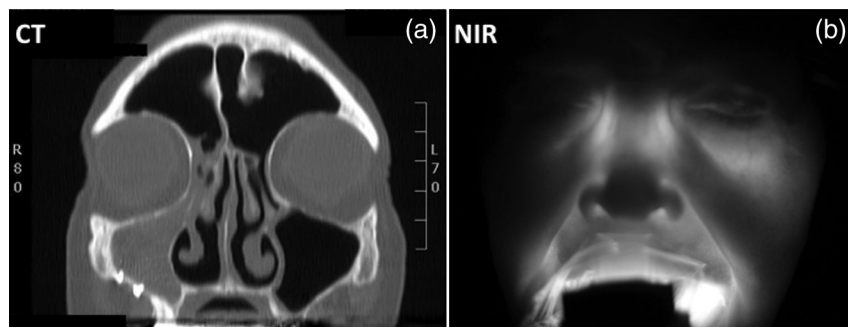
Example of near-infrared (NIR) optical imaging in the maxillary sinus. The patient presents a blocked right sinus as indicated in the computed tomography (CT) image slice (a). The patient's left sinus is clear as shown by the thin white lining in the void region (black). The patient's right sinus is completely filled (i.e., high opacity). The corresponding NIR image (b) mirrors the opacity of the CT image. The light source, composed of 850 nm LEDs, was placed inside the mouth to transilluminate the sinus. The bright aura around the mouth is due to source light leakage through the mouth area.
